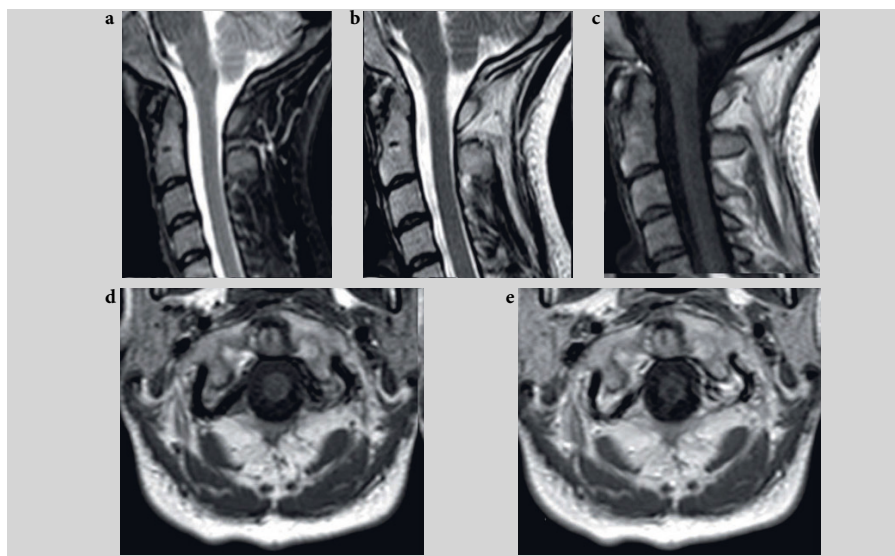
Magnetic resonance imaging (MRI) of the normal cervical spine of a patient with early rheumatoid arthritis. Sagittal short tau inversion recovery (STIR) (a); T2-weighted (b); and T1-weighted MRI (c) obtained before Gadolinium contrast injection; axial T1-weighted pre-contrast (d) and post-contrast (e) images. Images show a normal cervical spine. No signs of enhancing pannus or erosions in the C1/C2 junction are seen. Conventional radiographs were normal (not shown).
